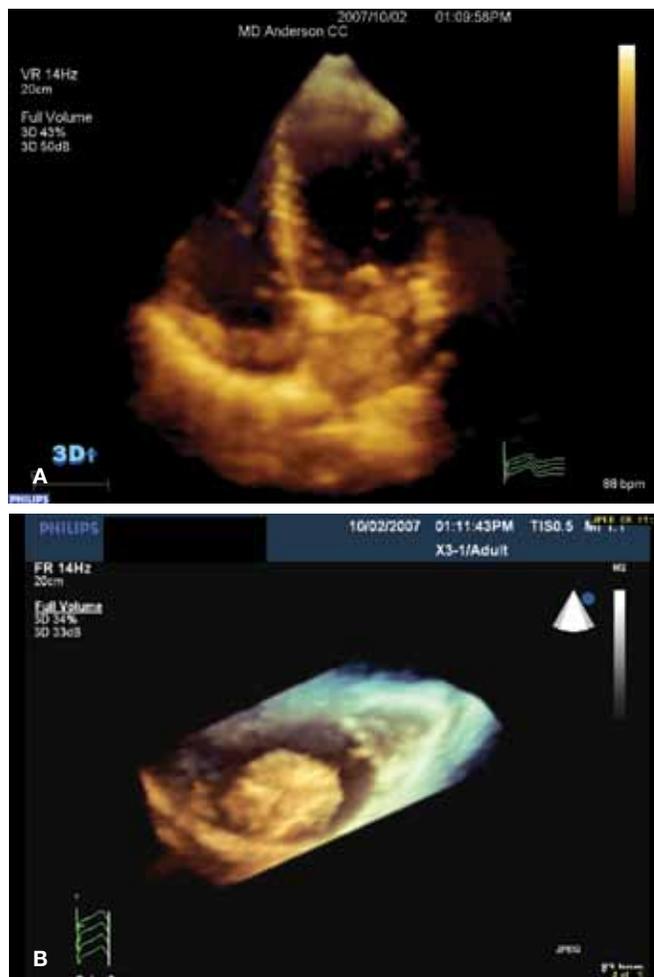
Full-volume acquisition (A) and cropped image (B) obtained from the apical 4-chamber view of a 22-year-old male with a recurrent metastatic osteosarcoma. The images show the tumor accessing the heart through the right upper pulmonary vein.
